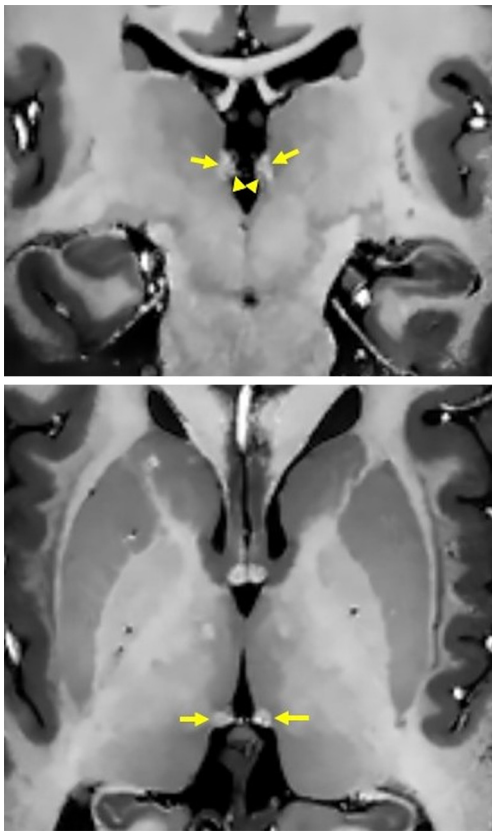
High-resolution T1WI (0.5 mm isotropic resolution) of the habenula (arrows) acquired using MP2RAGE after denoising (top: coronal, bottom: axial). On the coronal image, the lateral nucleus shows a slightly higher signal reflecting a shorter T1 value than that of the medial nucleus (arrowheads). T1WI, T1-weighted imaging; MP2RAGE, magnetization-prepared 2 rapid gradient echoes.
